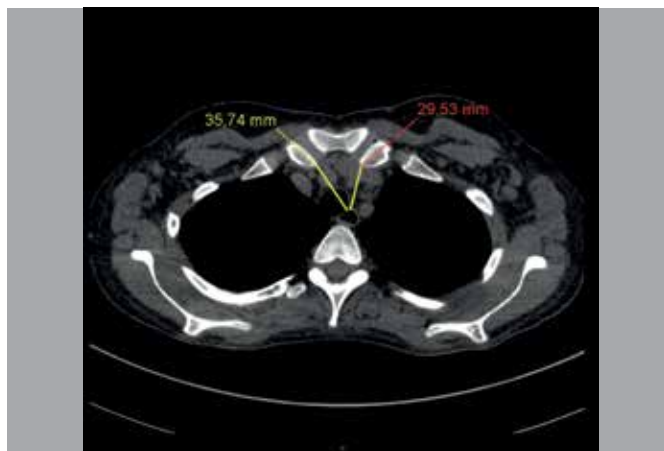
Axial computed tomography image demonstrating measurements of the sternoclavicular joints up to the esophagus.
